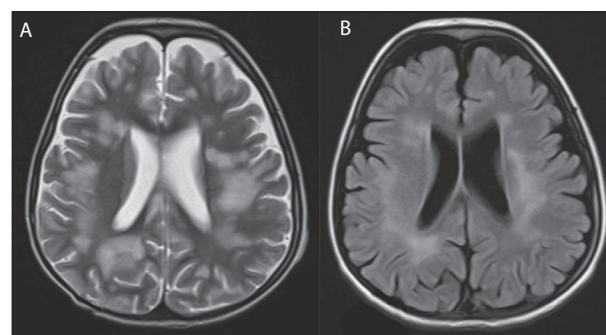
Acute disseminated encephalomyelitis in a four-year-old boy; A) T2W sequence of brain magnetic resonance imaging (MRI) scan shows large disseminated hyperintense lesions; B) follow-up brain MRI obtained 15 months later shows a decrease and no appearance of new lesions
